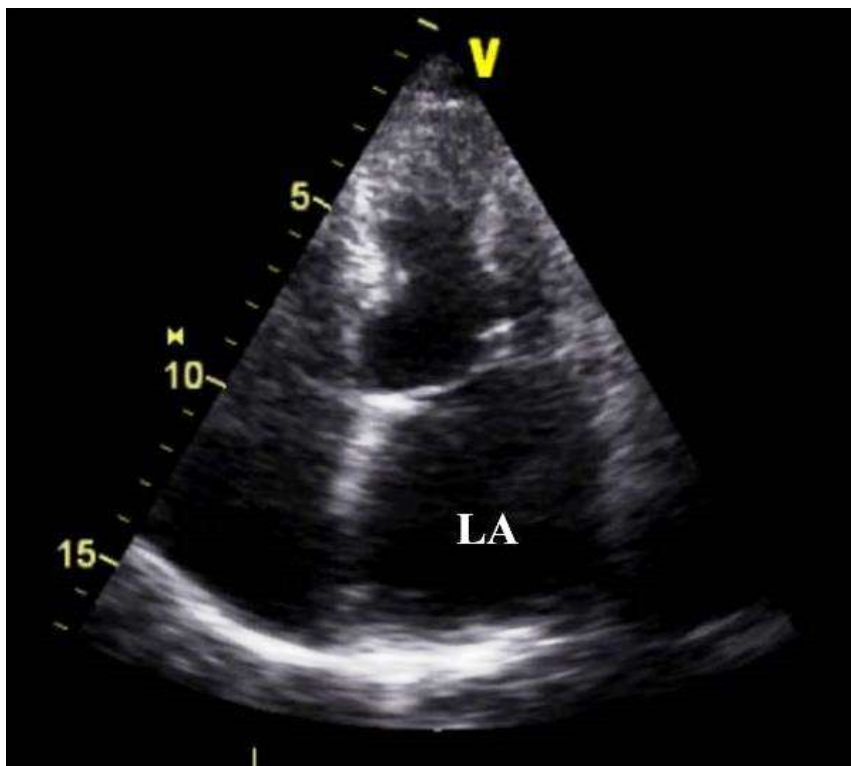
Transthoracic echocardiography displaying a left atrial (LA) dilation (courtesy of Rui Martins, MD, Cardiology Department).
